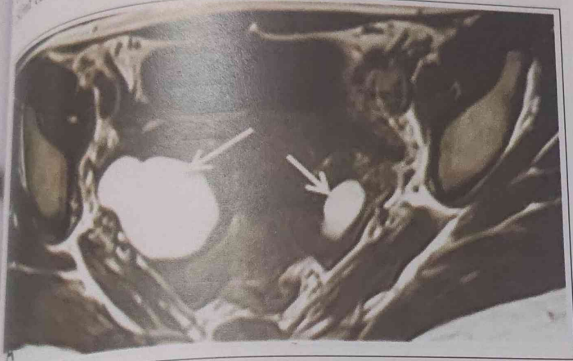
MRI showing endometrioma (Kind courtesy: Dr. Smita Manchanda, AIIMS, New Delhi)
